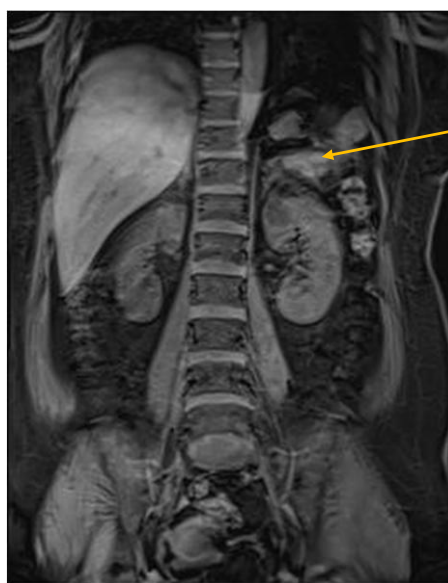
Contrast abdominal MRI
